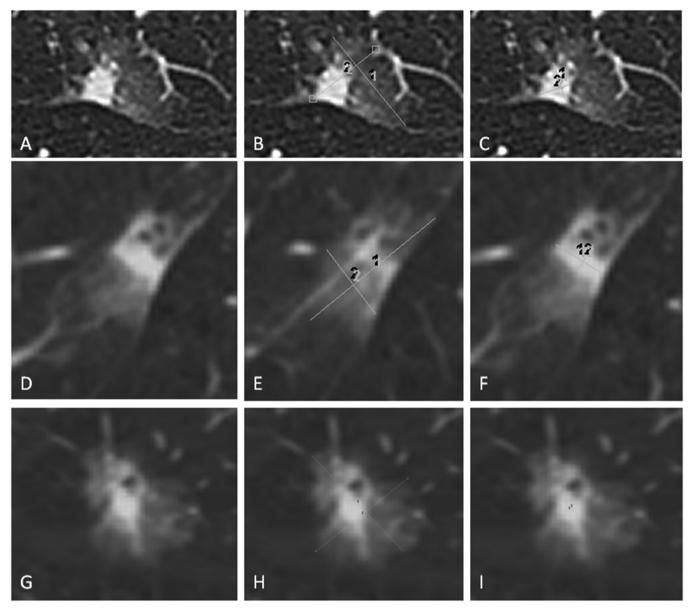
Measuring lesions on CT. (A–C) Axial CT images of a subsolid lesion with (B) measurement of the whole lesion in maximum long axis and a perpendicular measurement and (C) measurement of the solid component in maximum long axis and a perpendicular measurement. (D–F) The lesion and measurements taken in the sagittal plane. (G–I) The lesion and measurements taken in the coronal plane.
